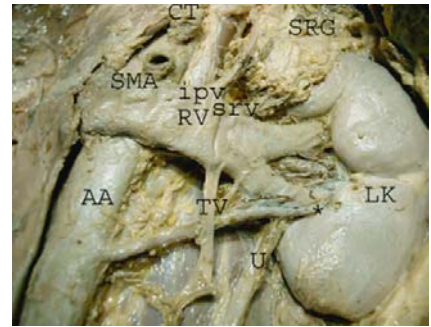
The accessory renal artery (inferior), LK: left kidney, RV: renal vein, RA: renal artery, TV: testicular vein, SMA: superior mesenteric artery, U: ureter, AA: abdominal aorta, CT: coeliac trunk, ipv: inferior phrenic vein, srv: suprarenal vein, SRG: suprarenal gland
